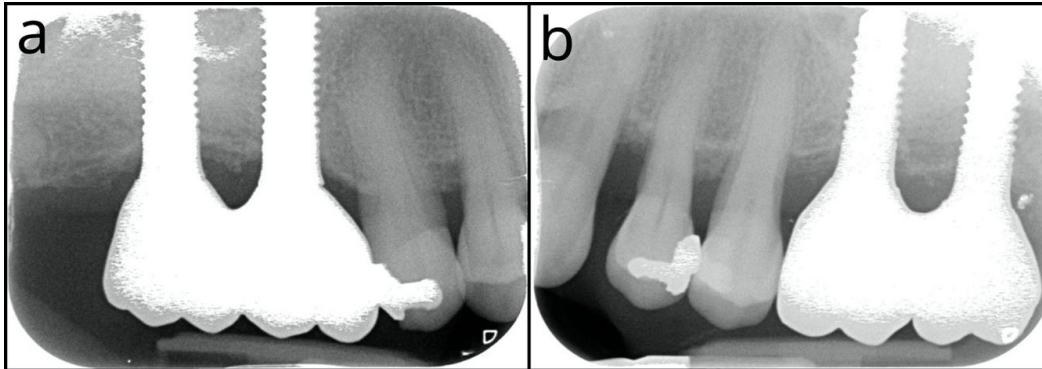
Radiographs performed after two years shows full integration of the implants. a. 1.6 and 1.7 positions. b. 2.6 and 2.7 positions.
